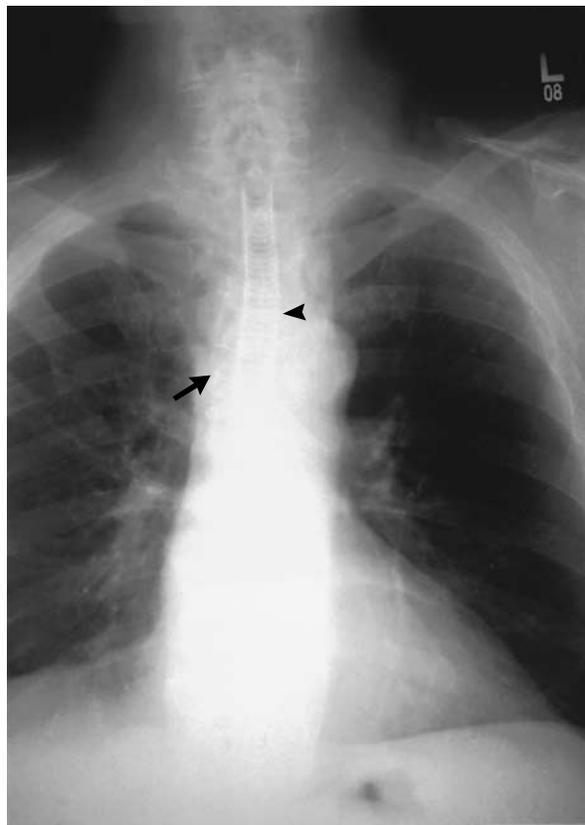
Posteroanterior Chest Radiograph of a 66-Year-Old Man with Diffuse Malacia of the Trachea and Main Bronchi Due to Mediastinitis after Coronary-Artery Bypass Surgery.
